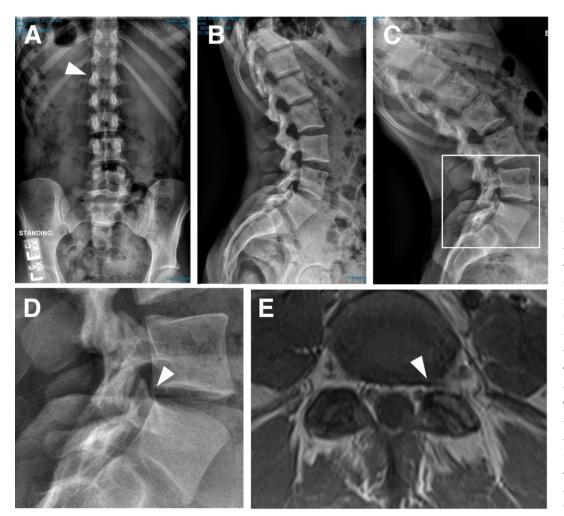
Imaging of the lumbar spine. A. Anteroposterior lumbar spine, showing lumbarized T12 (arrowhead). B. Lateral lumbar spine. C-D Lumbar extension, showing dynamic stenosis of the L4 intervertebral foramen and retrolisthesis of the L4 vertebra (arrowhead). E. MRI (T1-weighted image) revealed mild static stenosis of the left L4 intervertebral foramen (arrowhead).
